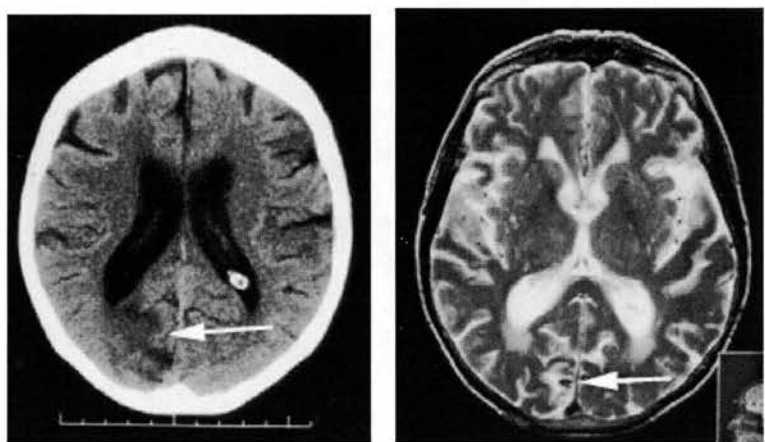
62 year old man with right arm weakness and expressive dysphasia, mostly resolved. Scanned at 28 days. CT on left, gradient echo MRI on right.
